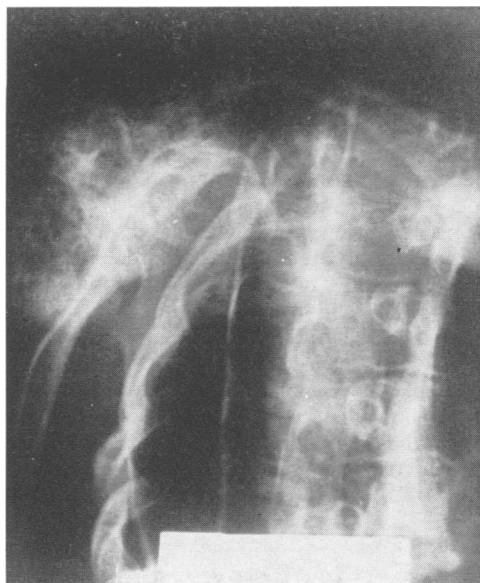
X-ray of chondrosarcoma of scapula in IV-27.
